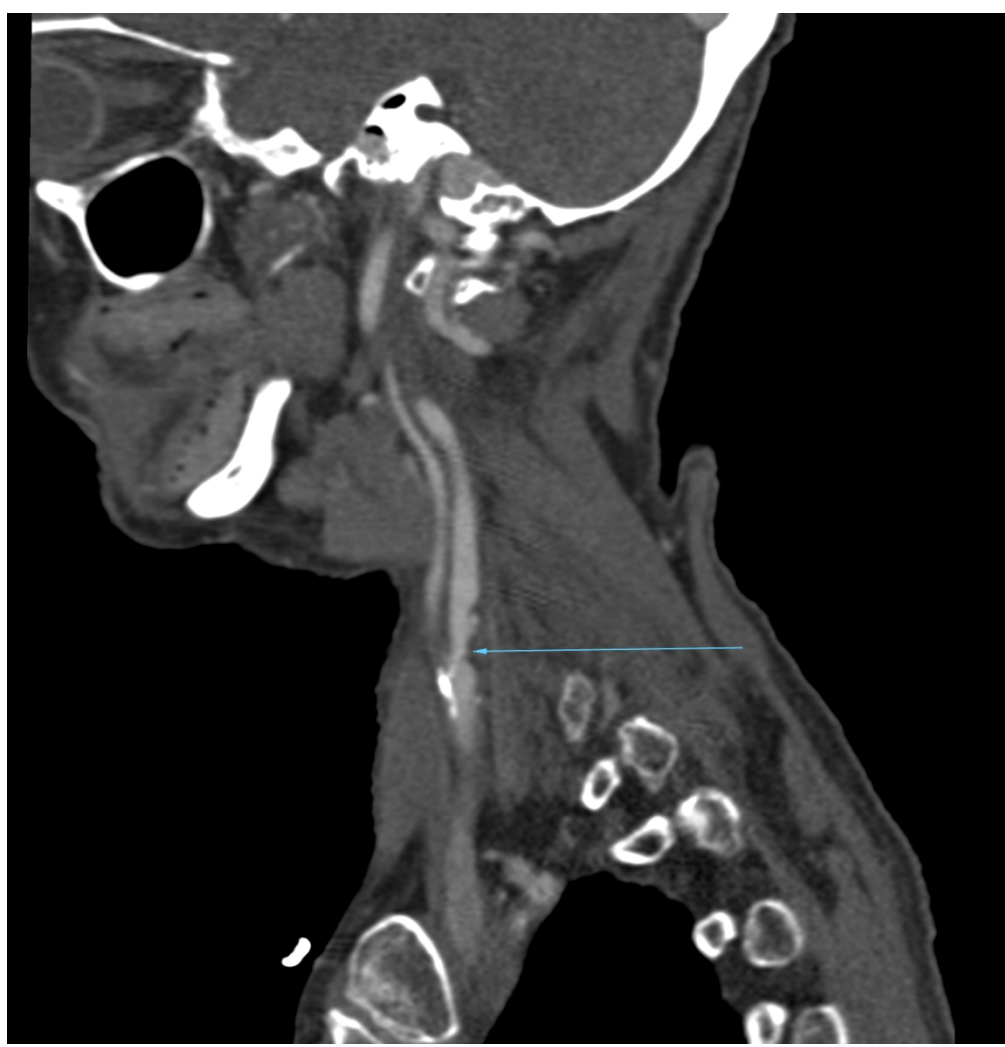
(a): CTA shows a moderate (~50%) stenosis of the left proximal internal carotid artery (blue arrow) in a recently symptomatic stroke patient presenting with right sided weakness and dysphasia.
